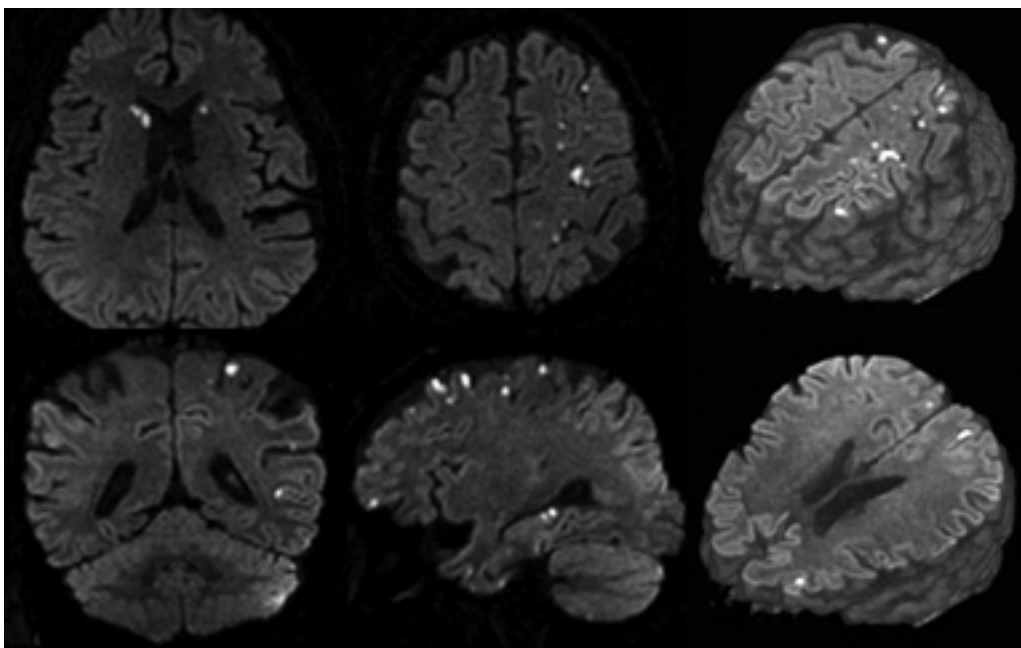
Volume DWI can decrease geometric distortion and susceptibility artifacts in coronal images.
